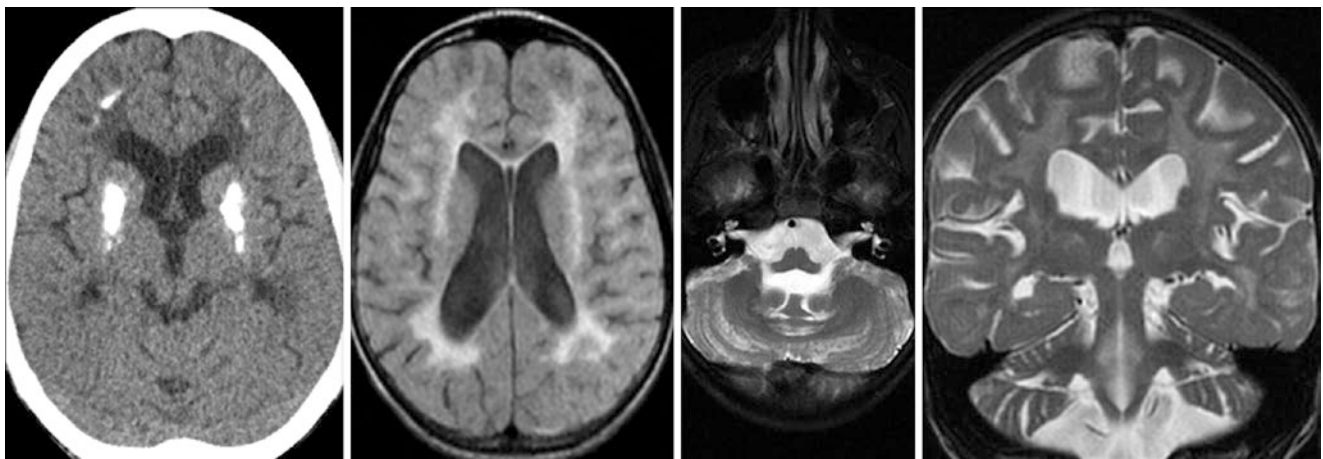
Comparison case of Cockayne syndrome. A 13-year-old male had severe BG calcifications and subcortical calcifications that were quite disproportionate to his age on a NECT (*left*). A 1.5T MRI
